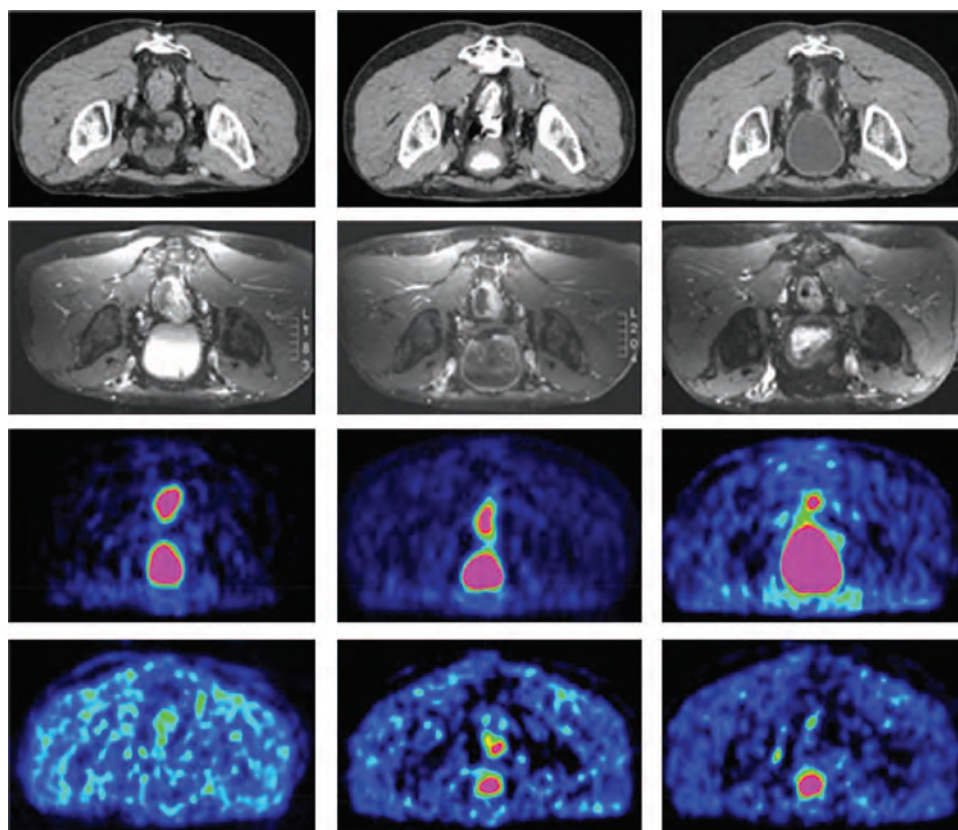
Comparison among various modalities for the definition of a primary-rectal-tumor GTV before (left), during concomitant chemoradiotherapy (center), and after radiation therapy (right). Positron emission tomography–computed tomographic acquisitions were performed in a prone position using a belly board; MRI acquisitions were performed in a supine position. (Figure courtesy of Prof. K. Haustermans, Katholieke Universiteit Leuven, Belgium.)
